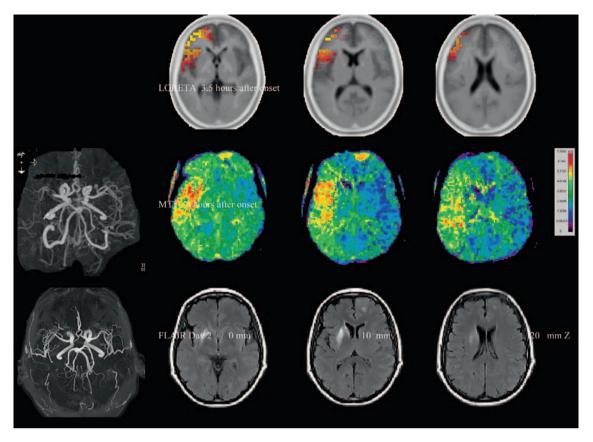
The images are shown in neurological convention with the left side being on the left. The region of abnormal electrical activity on the LORETA images at 3.5 h underestimate the perfusion deficit seen in the mean transit time (MTT) image in the temporal lobe and striatocapsular region. Follow-up MRI fluid-attenuated inversion recovery (FLAIR) images on day 16 showed a left striatocapsular infarct but none in the left frontotemporal cortical region.
